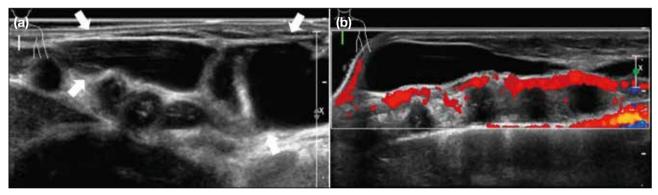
A 1-month-old male infant found to have a soft fluctuant right anterior chest wall mass since birth. (a) Targeted ultrasound (US) revealed a multilocular anechoic cystic mass with lobulated margins and posterior acoustic enhancement at the subcutaneous layer with no solid component (arrows). (b) Colour Doppler US shows no internal vascularity within the mass. Features were consistent with lymphangioma.
